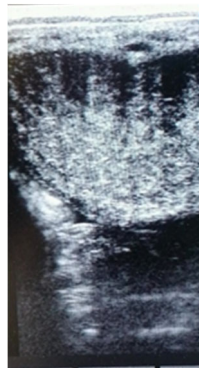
Ultrasonogram of left uterine horn of a mare 1 year after cyst ablation
